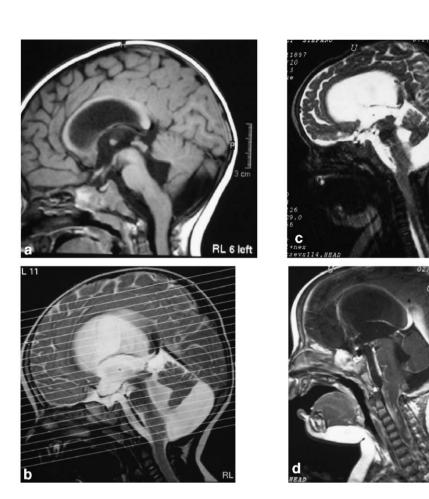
a Cerebral sagittal T₁-weighted MR image showing a 3-cm, well-delineated cyst in the posterior fossa and hydrocephalus. b Cerebral sagittal T₂-weighted MR preoperative endoscopic image showing progression of the hydrocephalus. c Cerebral and cervical sagittal T₂weighted MR image showing the cervical spinal swelling cord up to the C5 suggesting the diagnosis of an intraspinal tumor. d Sagittal T₁-weighted MR images with gadolinium injection performed after tumor operation. Note the significant progression of ventricular and meningeal neoplastic dissemination and lack of control of hydrocephalus.
